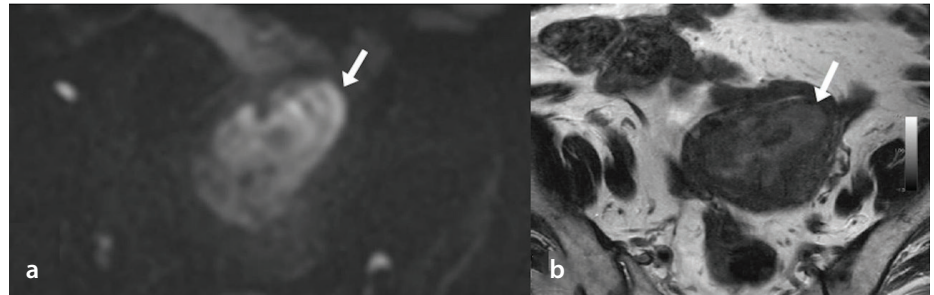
In a 69-year-old patient with a mixed tumor consisting of grade 1 endometrial adenocarcinoma of the endometrioid type and undifferentiated carcinoma, a mass lesion causing expansion in the uterine cavity is observed on MRI (white arrows). On DWI, the mass shows high signal intensity (a), whereas in T2-weighted oblique axial sections (b), it shows slightly higher signal intensity than the muscle. The lesion was concluded to have SMI, but pathological evaluation revealed DMI. MRI, magnetic resonance imaging; DWI, diffusion-weighted imaging; SMI, superficial myometrial invasion; DMI, deep myometrial invasion.
